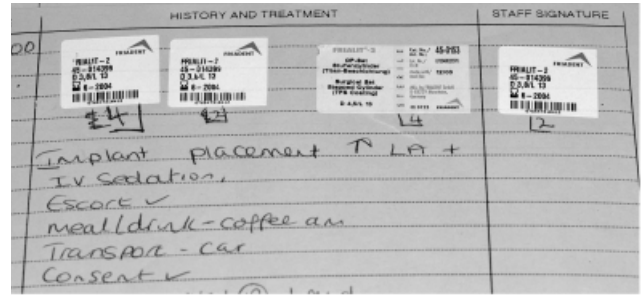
Example of a patient's record detailing implant placement, the batch numbers of the implants placed and an accompanying radiograph of the postplacement maxilla. Note the lack of features in the atrophic mandible.
